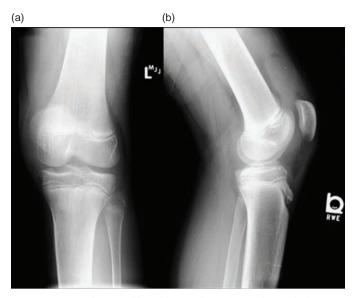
(a, b) AP and lateral knee radiograph revealing a tibial eminence injury
